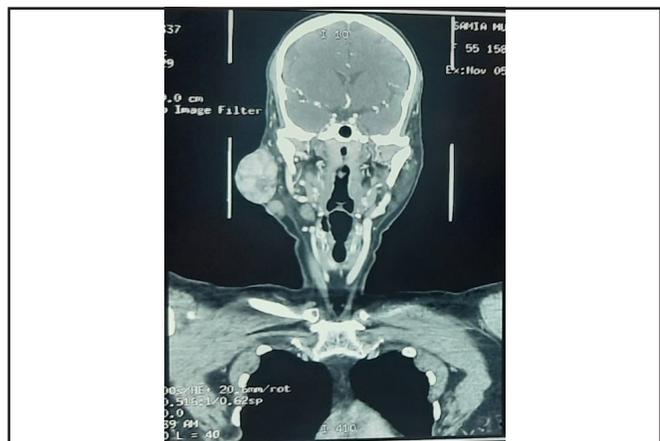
CT scan coronal image showing an enhancing mass involving right parotid gland.
